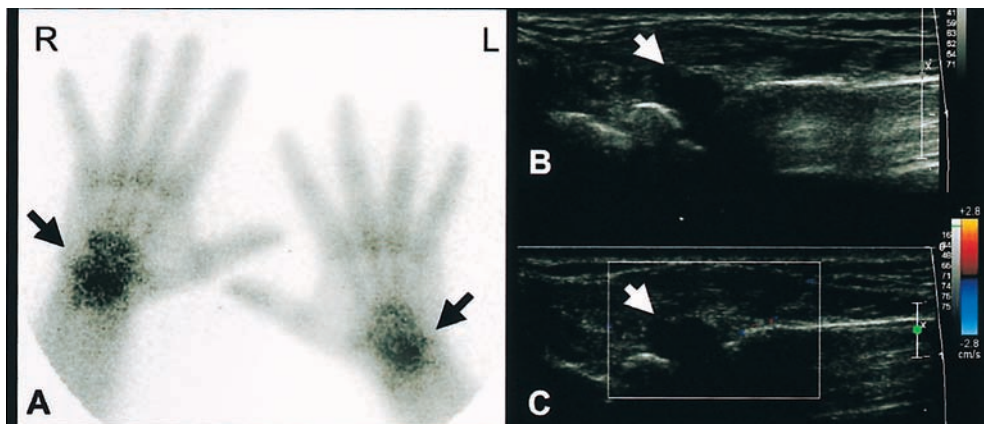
28-year-old male patient: clinical assessment showed an oligoarthritic form, while total-body bone scintigraphy demonstrated a polyarticular pattern. In particular, on bone scintigraphy (A) the wrists showed increased uptake (arrows) in the absence of symptoms or signs of clinical involvement. B-mode ultrasonography (B) of the left radio-carpal joint demonstrated gray-scale changes of synovial hypertrophy (arrow); on the echo-color Doppler scan (C) note the absence of hyperemia (arrow).
